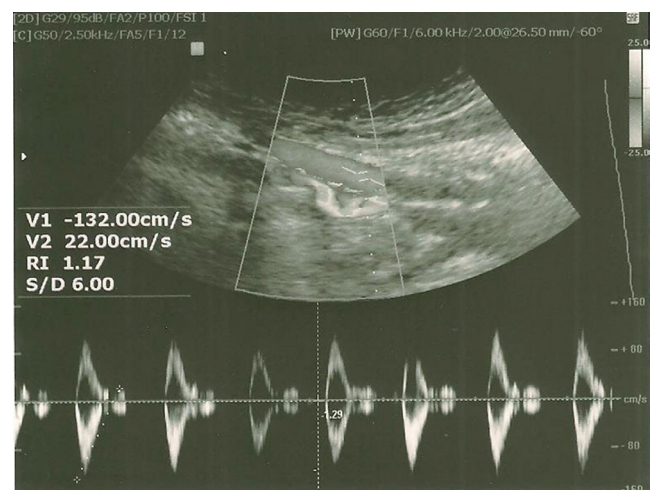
Doppler ultrasound of the right iliac artery. Normal flow pattern in the right common iliac artery
